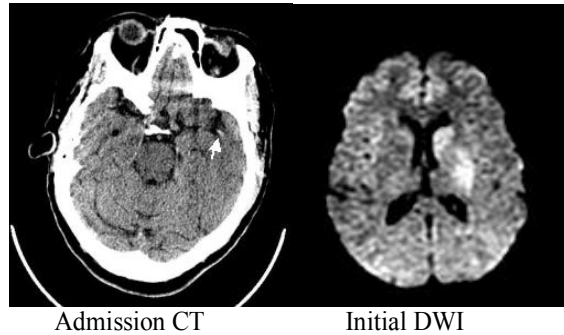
A 73-year old female with right hemiparesis and aphasia. The admission CT showed left dot sign in the right Sylvian fissure. The initial DWI and ADC (15 minutes after
